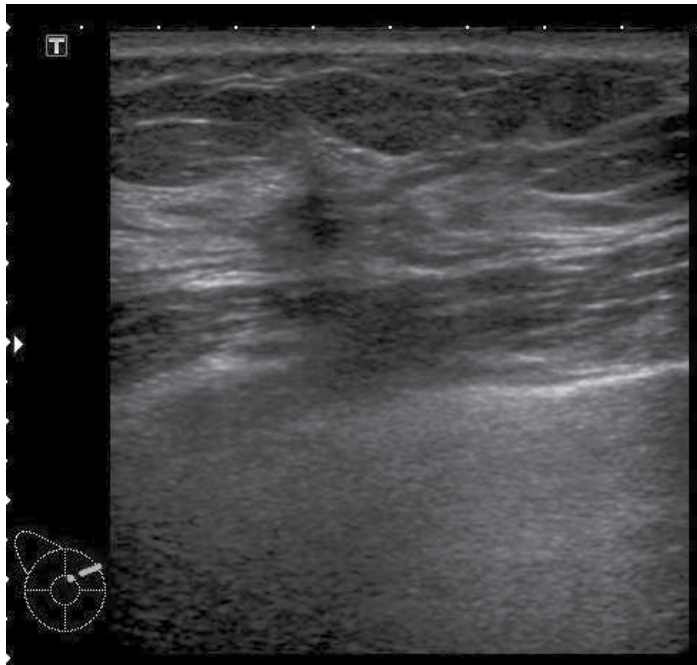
A first representative case of DCIS, Ultrasound.
